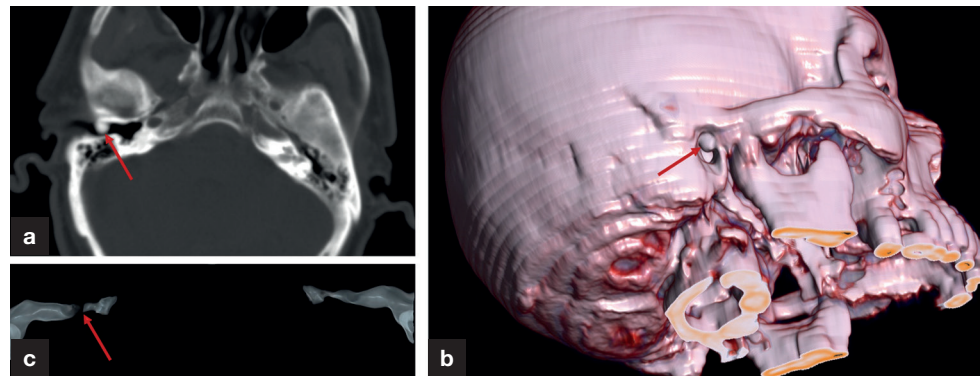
a. Axial computed tomography scan and (b) right lateral oblique three-dimensional volume-rendering computed tomography image showing hyperdense osteoma (arrows) in the right external auditory canal. c. Air-specific volume-rendering three-dimensional computed tomography image showing obliteration (arrow) of the right external auditory canal.
